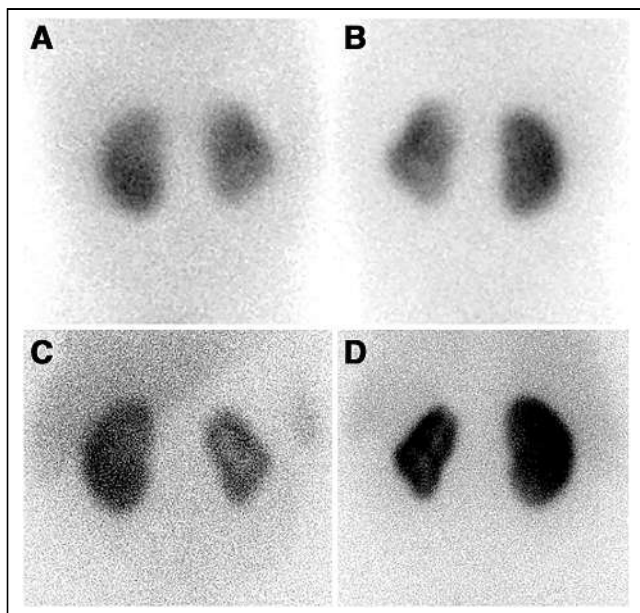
(A and B) Anterior (A) and posterior (B) ^{99m}Tc -DMSA images obtained in a 20-mo-old child showing a small left kidney with probable areas of superior and inferior pole scarring. A dromedary hump is also seen on the left kidney, and is most consistent with an anatomic variant based on correlation with ultrasound. (C and D) Anterior (C) and posterior (D) scintigraphic images obtained in the same patient at 13 y old, showing a similar appearing small left kidney, but now with mild diffuse radiotracer activity throughout the liver and spleen.
